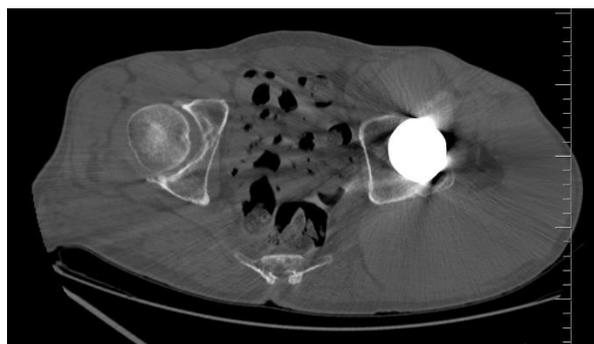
CT of the hip showed a large gluteal mass around the prosthetic components
